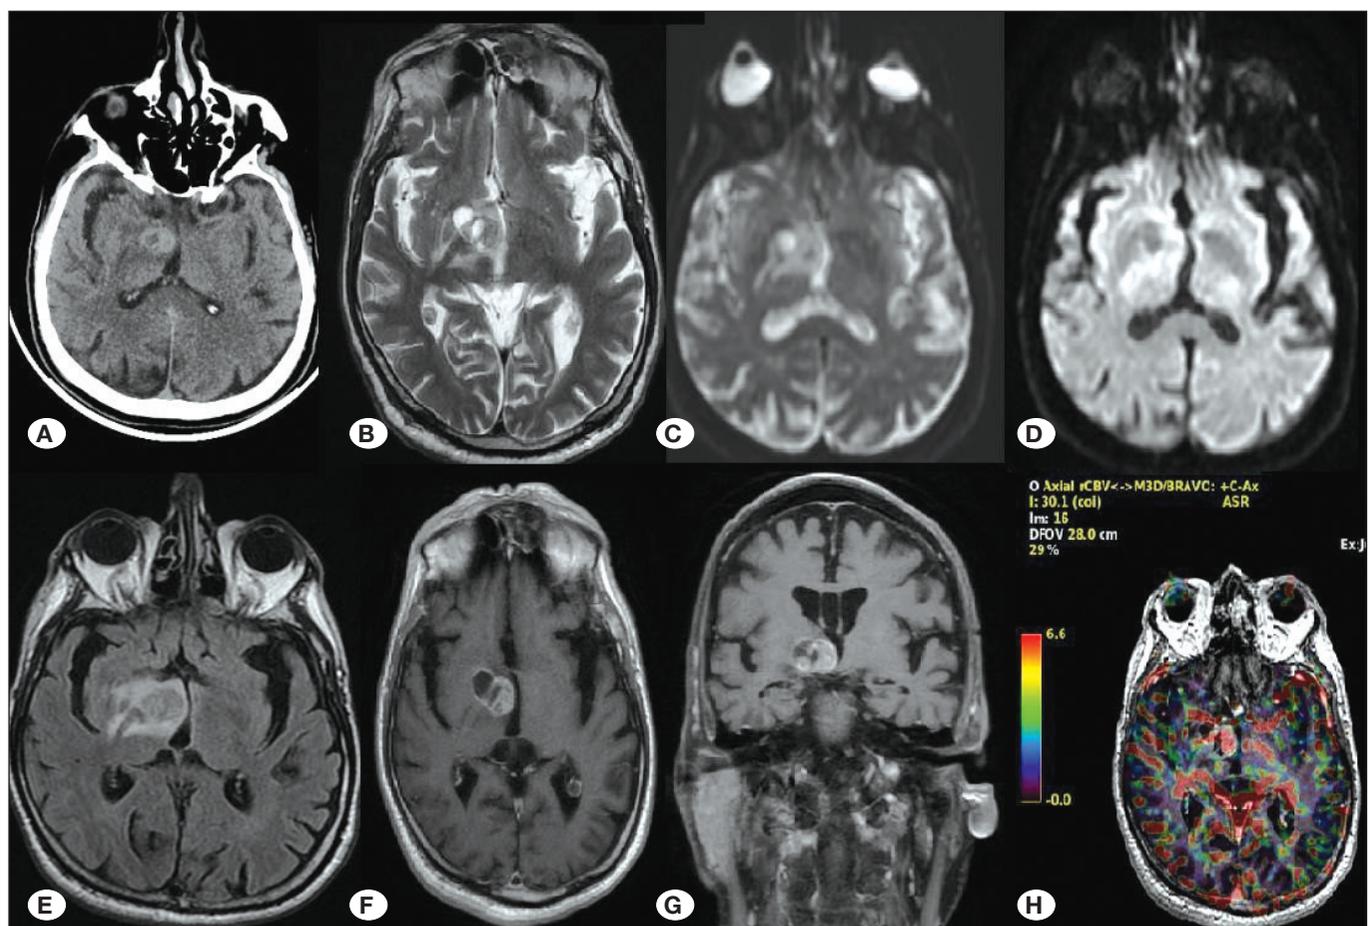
A) Axial section CT, B) axial T2W MRI of the brain, C) axial diffusion MRI, D) axial section FLAIR MRI of the brain. E) 1st month axial section T1W MRI of the brain, F) 1st month contrast enhanced T1W axial brain MRI, G) 1st month contrast enhanced T1W coronal brain MRI, H) 1st month perfusion weighted MRI of the brain.
